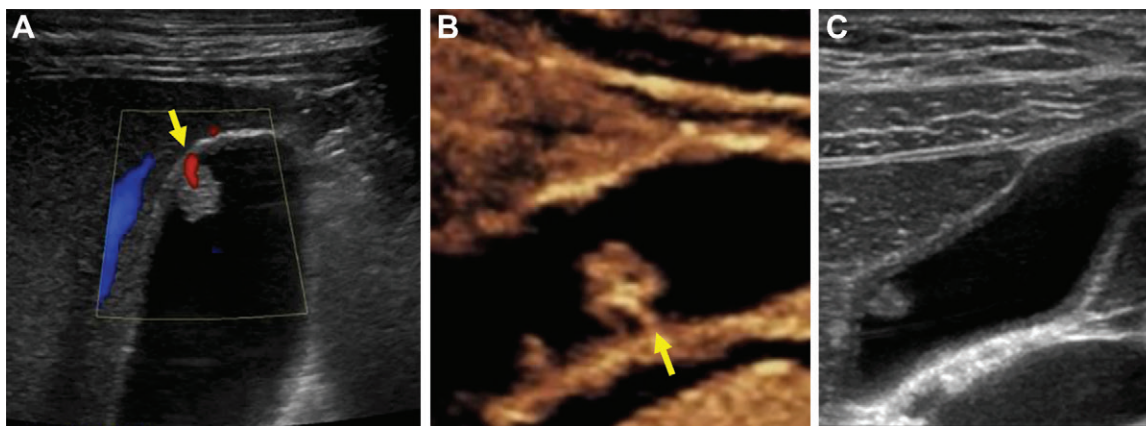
(A) Color Doppler, (B) contrast-enhanced, and (C) gray-scale US images show three examples of pedunculated polyps with a thin stalk. A thin stalk may be nearly invisible at gray-scale imaging but inferred to be present or visualized with color or power Doppler (arrow in A), other flow-sensitive techniques, or contrast-enhanced US (arrow in B). A polyp occasionally can be seen wiggling in place, which implies a thin stalk (C). A pedunculated polyp with thin stalk should be categorized as an extremely low risk polyp. In the extremely low risk category, no follow-up is recommended for polyps of 9 mm or smaller; follow-up US at 6, 12, and 24 months is recommended for polyps measuring 10–14 mm; and surgical consultation is recommended for polyps of 15 mm or larger. If at follow-up, a polyp has increased in size by 4 mm or more within a 12-month period or reaches 15 mm, surgical consultation is recommended.
